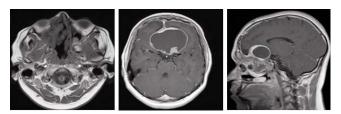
Post-op MRI (6-months post-op) shows debulking of the nasal component of the lesion. There is a large intracranial and paranasal sinus residual disease which appears grossly unchanged.
